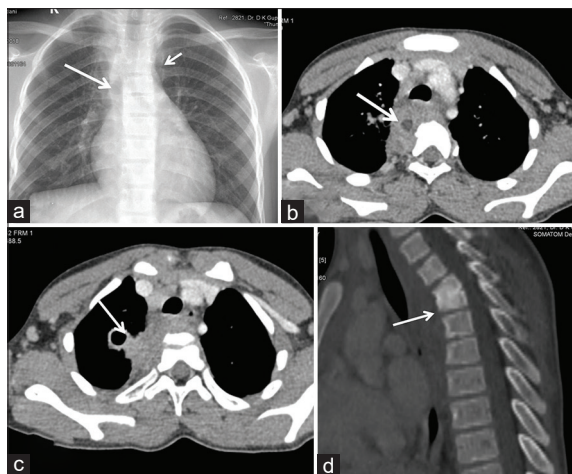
(a) Chest X-ray posteroanterior view shows well-marginated soft-tissue opacity with convex margin seen in the right paravertebral region (large arrow) with fusion of D3–D4 vertebra (small arrow). (b and c) Contrast-enhanced computerized tomography axial view depicts the heterogeneously enhancing soft tissue in the pre- and paravertebral region showing areas of necrosis (arrow in b) with adjacent lung infiltration and cavity formation in the right upper lobe (arrow in c). (d) Sagittal reformatted sections of the bone window show fusion of D3–D4 vertebra with the presence of bony sclerosis
